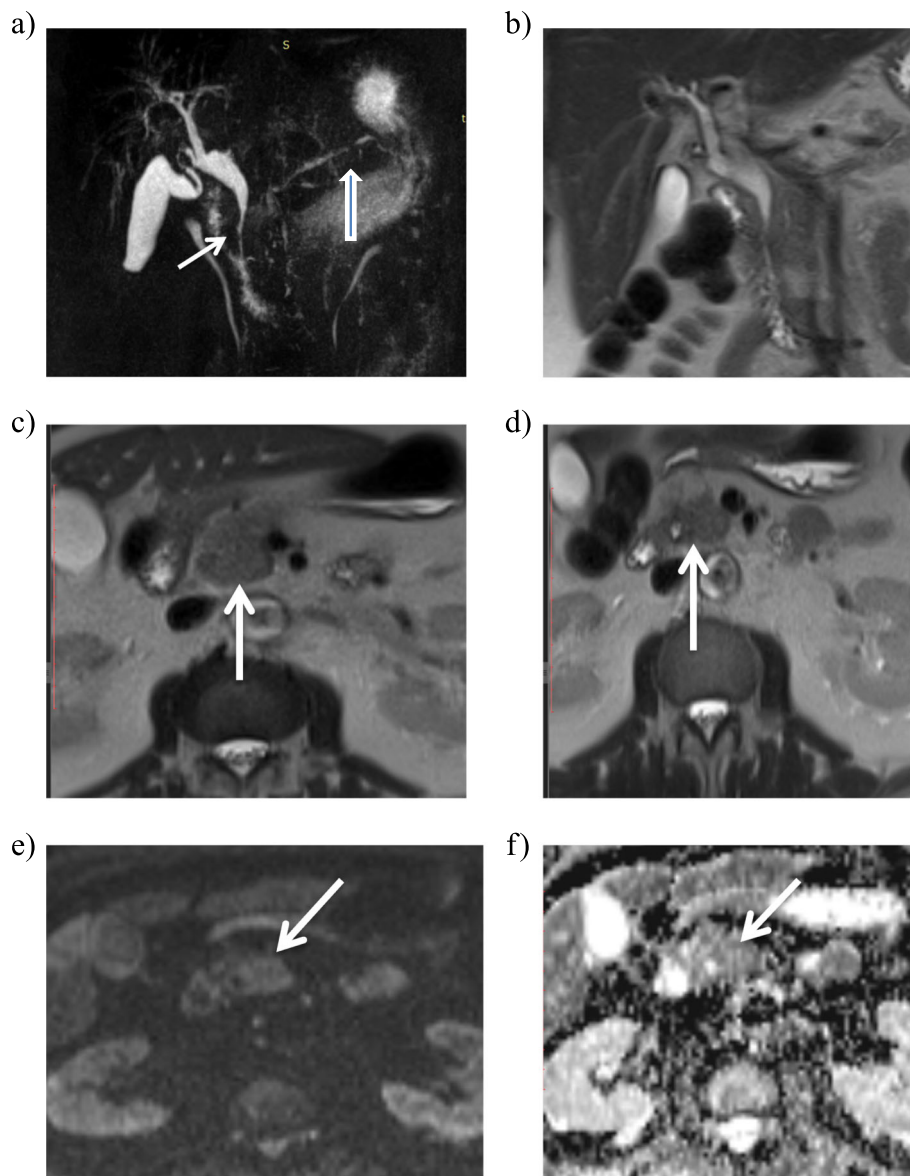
A 65-year-old male patient with IgG4 related bilio-pancratitis. a 3D T2 coronal thick slab MRCP image showing intra- and extrahepatic biliary dilation with distal CBD (intra-pancreatic segment) long strictures (25 mm), showing regular borders still abrupt transition, multifocal strictures, and ectasia of the main and side pancreatic ducts (thick arrow). b Coronal T2 HASTE showing an ill-defined iso-intense 2 cm lesion at the pancreatic head at the site of the stricture (thick arrow). c, d DWI and ADC map showing no restricted diffusion (thin arrows). e Coronal contrast enhanced CT image showing abnormal smooth enhancement of the distal CBD (long arrow). f Axial contrast enhanced CT image showing ill-defined hypo-enhancing pancreatic head lesion (thin arrow)
